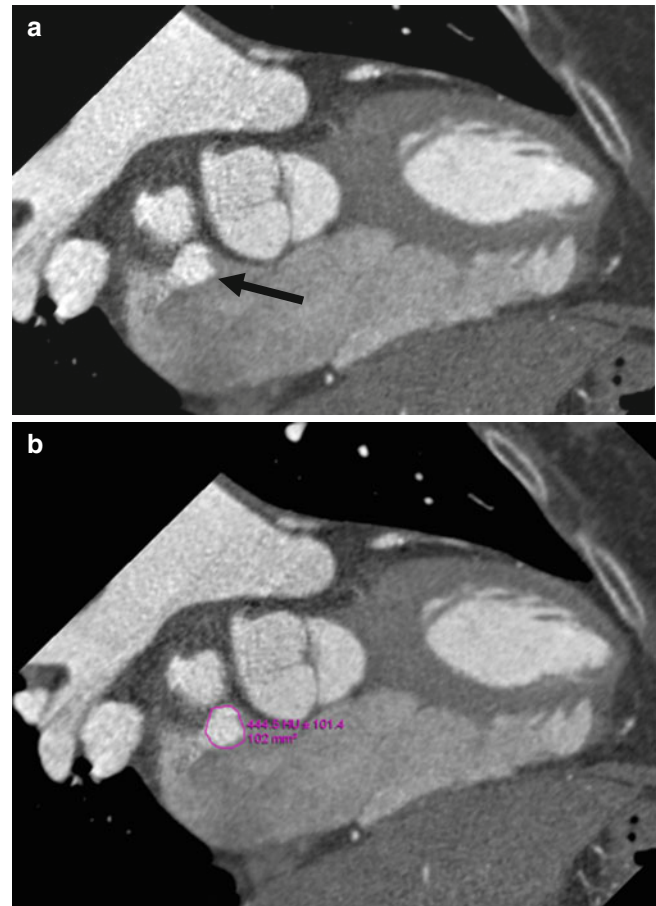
Measurement of the atrial septal defect (ASD) area. Oblique en face views allow measurement of defect dimension and area. CT images should be reconstructed so that the maximum size of the defect in long and short axis can be visualized and measured with electronic calipers at the workstation. Usually, an oblique reconstruction with en face view of the ASD suffices. Measurements are made at end systole to obtain the greatest size of the ASD. The area is automatically calculated by tracing the electronic calipers along the circumference of the ASD. Circle Traced area of the ASD, *black arrow* ASD
